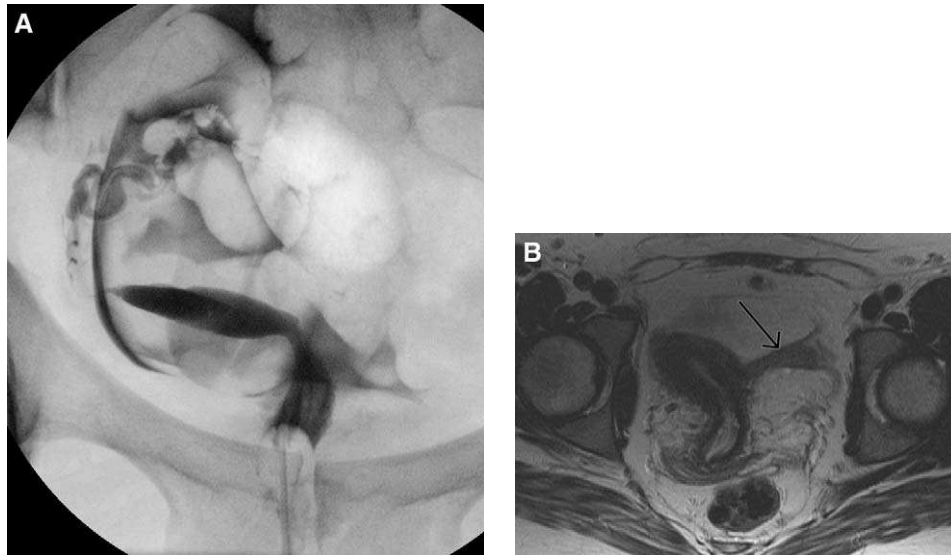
Unicornuate uterus by hysterosalpingography (A) and MR imaging (B). Note the nonfunctioning rudimentary horn (arrow).
